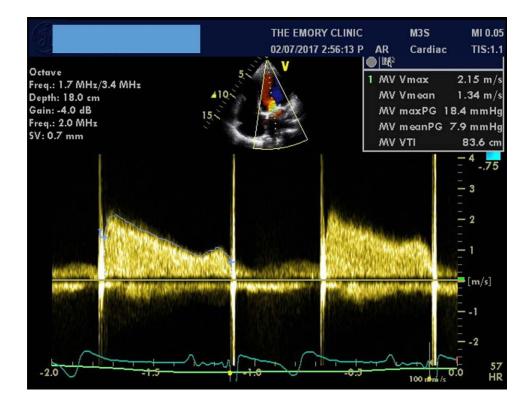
TTE 1 mo postpartum reveals reduced MV meanPG 8 mm Hg across the MMV indicating less severe functional mitral stenosis and return of prepregnancy physiology. MMV indicates mechanical mitral valve; TTE, transthoracic echocardiography.
